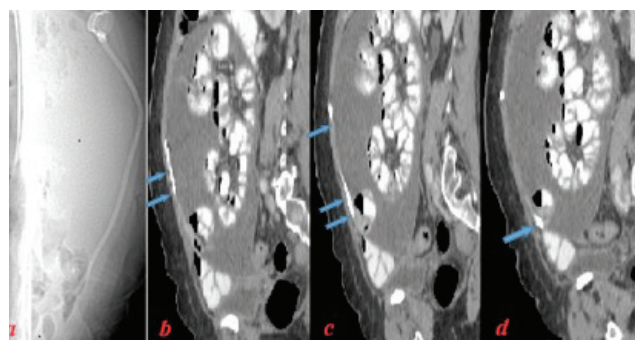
Abdominal Computed Tomography: Adhesive sheet around the catheter (case #2); localization of catheter (a); arrow: catheter filled with contrast; there were no spread to intra-abdominal cavity (b, c, d) and at the tip of the catheter the saccular structure was shown (d)
